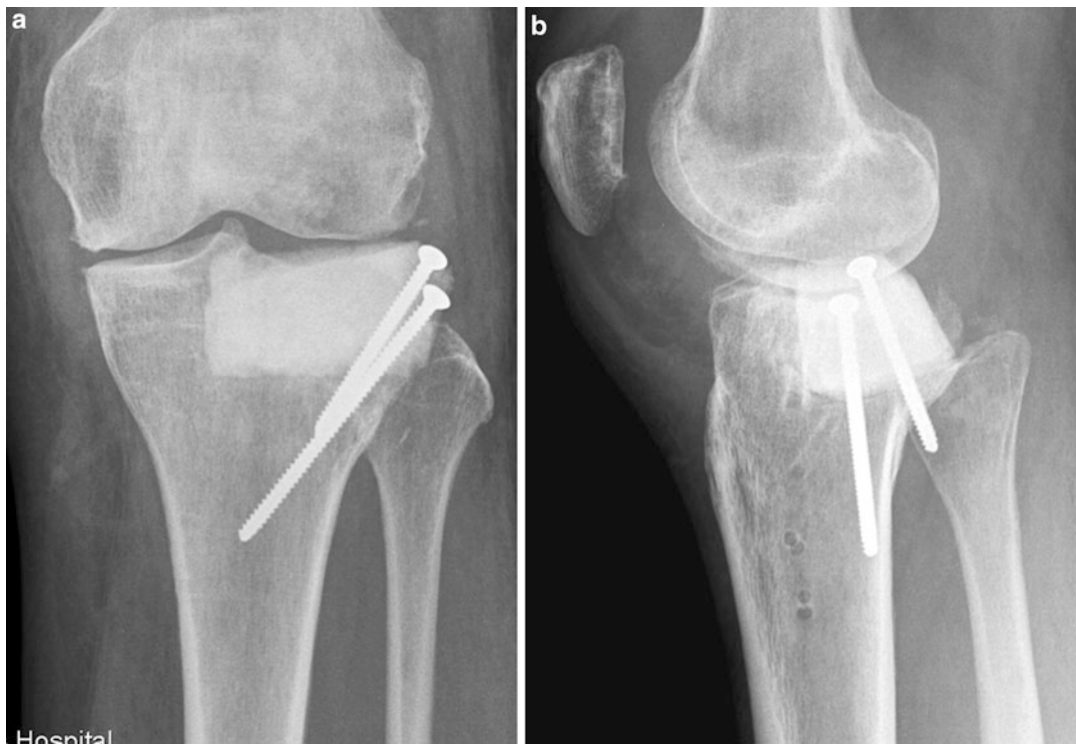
AP (a) and lateral (b) radiographs following first stage, debridement and temporary reconstruction with antibiotic PMMA spacer. Two divergent screws provide adequate stabilization of the PMMA spacer
